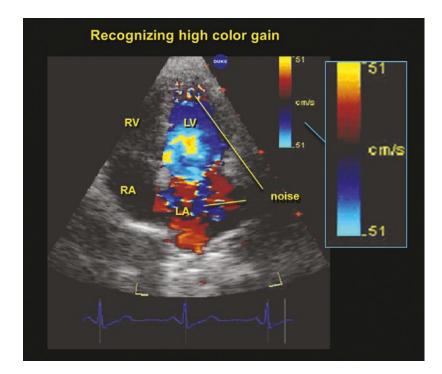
Apical four chamber view with markedly excessive color gain that renders the color flow unintelligible. Note the excess color gain makes the tissue around the apex sparkle
